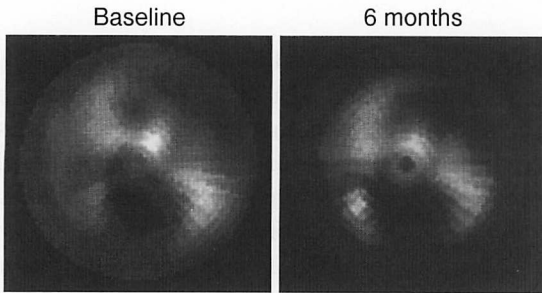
Iodine-123 BMIPP myocardial SPECT bull's-eye images before treatment and after 6 months in Nonresponder 4
